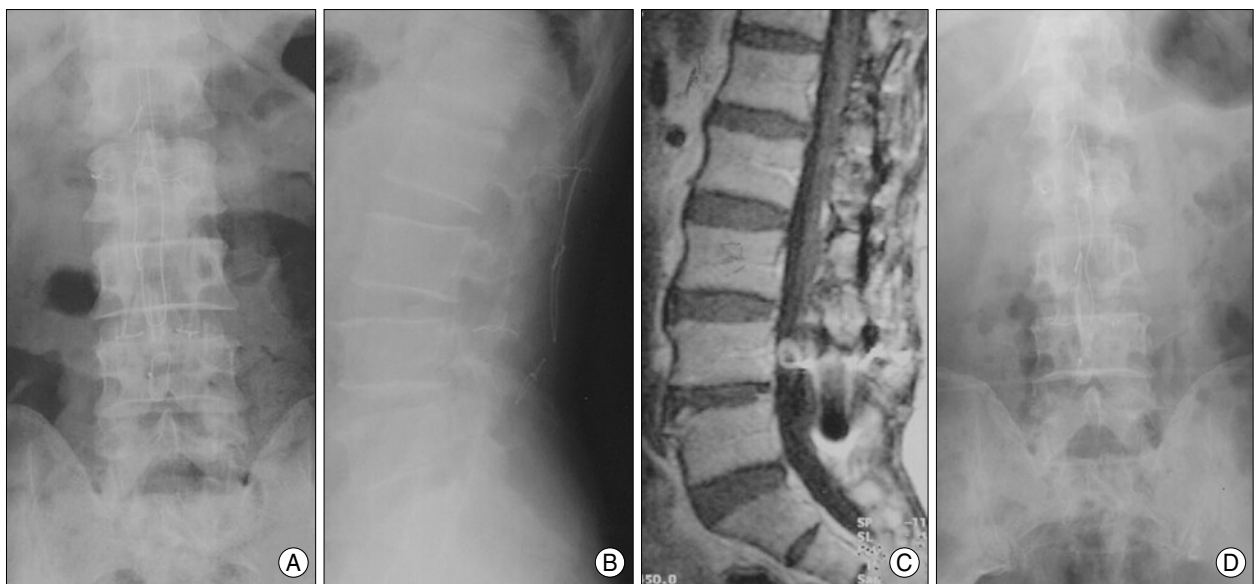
A 70 year-old man with intradural extramedullary tumor on L4 level before and after removal of tumor and laminoplasty. A, B : Postoperative X-rays show L4 laminoplasty state with wiring on L1-4 level due to previous operation caused by schwannoma before 8 years. C : Preoperative magnetic resonance image showing intradural extramedullary mass-like lesion on L4 level. D : Second postoperative X-ray shows L4 laminoplasty revision state.
